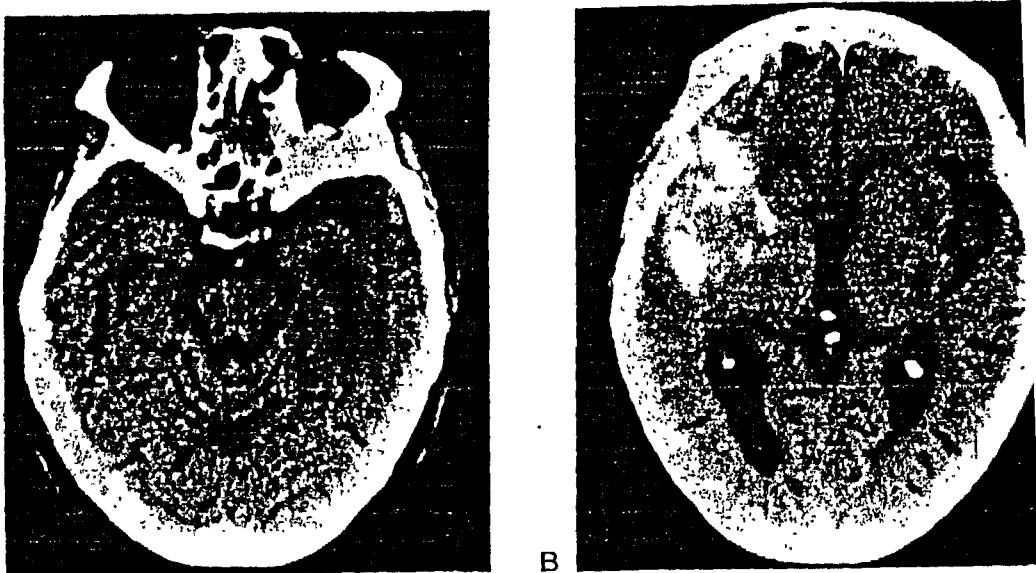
Computed tomography scans in a hypertensive patient:
